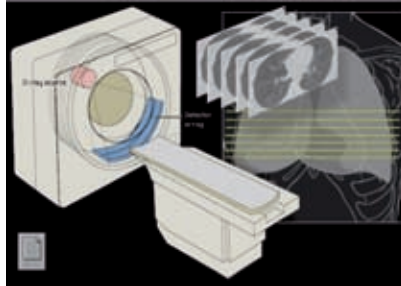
Images produced by CT examinations are of very high quality
